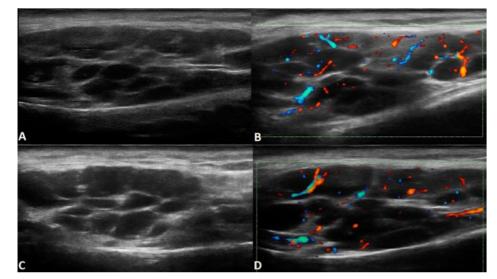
(A, B, C, D): Right parotid gland grey scale (A) and power Doppler (B) with marked inhomogeneous pattern and hypervascualarity. Left parotid gland -grey scale (C) and power Doppler (D) -the same cystic aspect with grade 2 power Doppler signal
